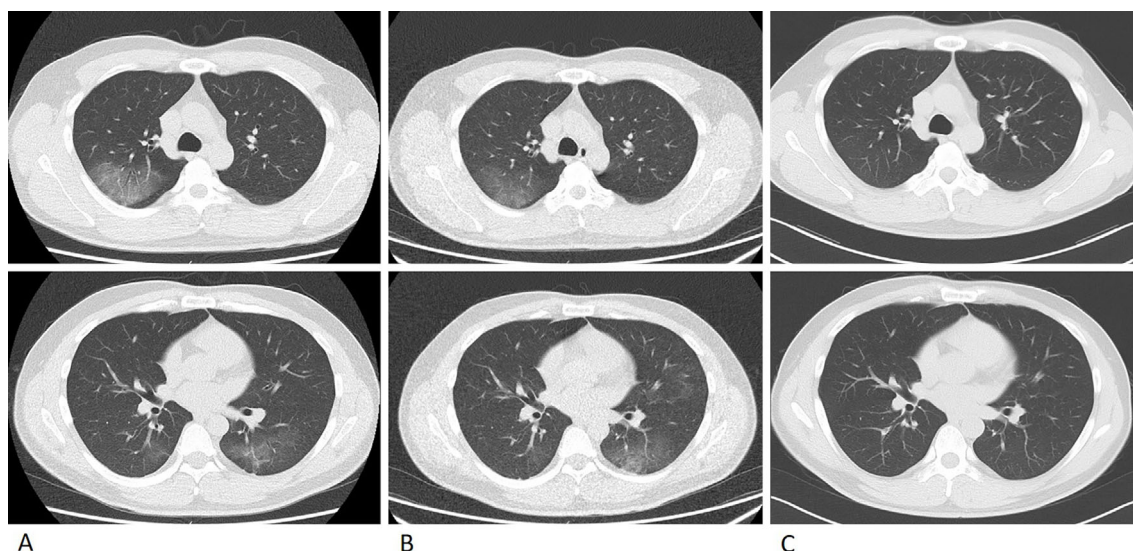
A: Pre-admission screening CT. Patchy ground-glass opacities are noted. B: Two months after (A), there is an improvement in the upper lobe opacity and a mild worsening of the lower lobe opacity. C: Two months after the surgical repair of the CSF rhinorrhea, a complete clearance of the lung opacities is observed.
